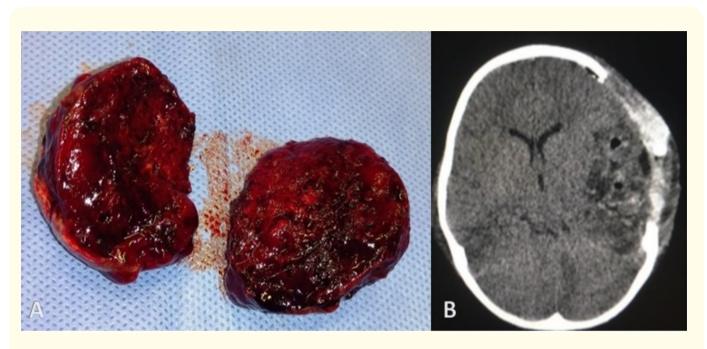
A: Postoperative photography showing a resected tumor with hemorrhagic appearance. B: Postoperative brain CT scan, where we can observe a satisfactory tumor resection and a decompressive craniectomy.
